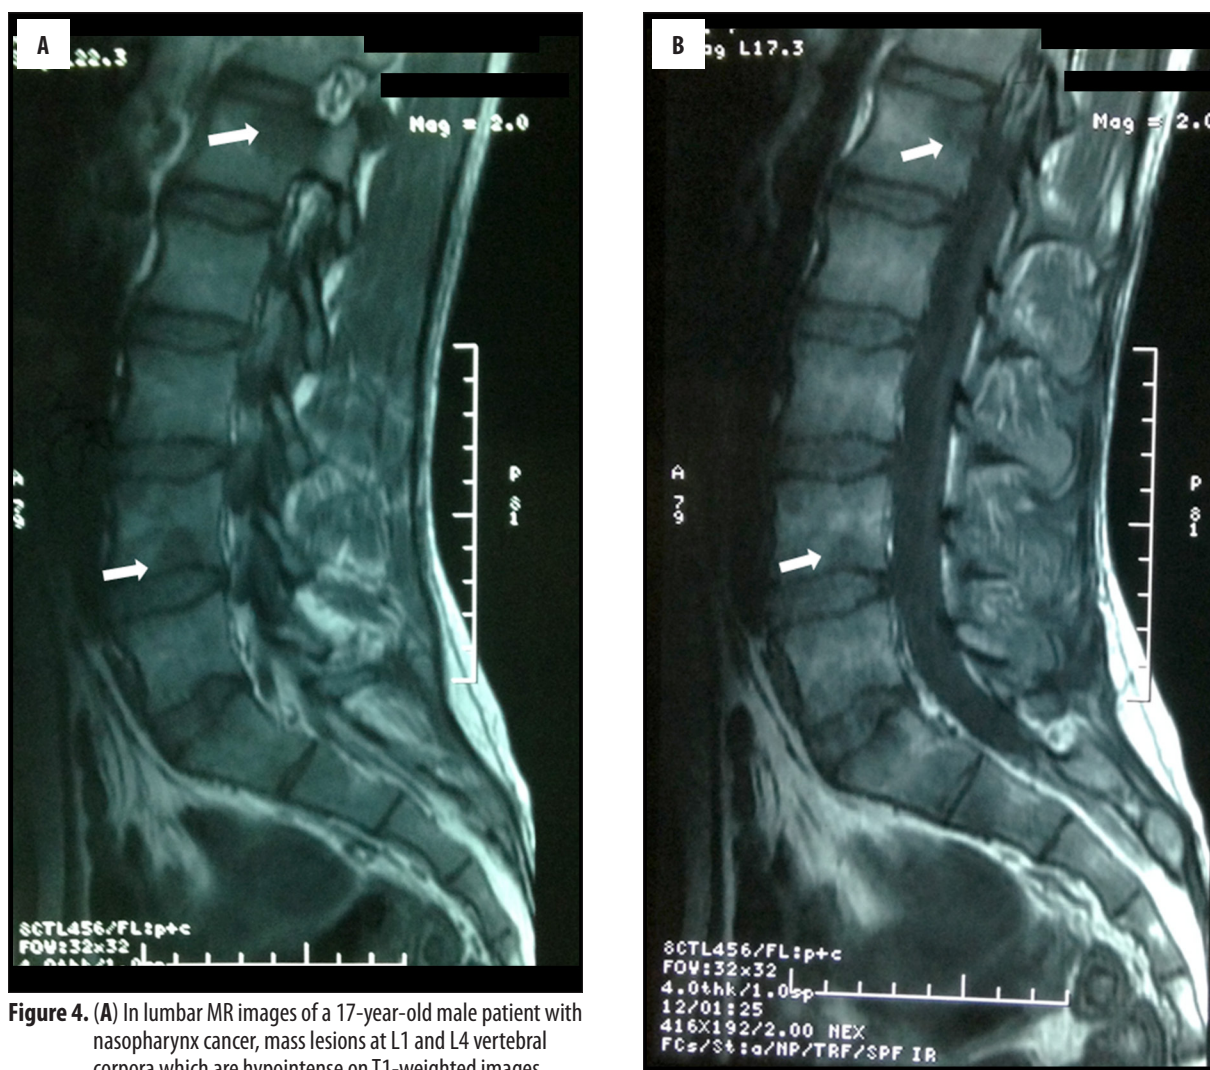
(A) In lumbar MR images of a 17-year-old male patient with nasopharynx cancer, mass lesions at L1 and L4 vertebral corpora which are hypointense on T1-weighted images, and (B) minimal enhancement observed after contrast administration.
